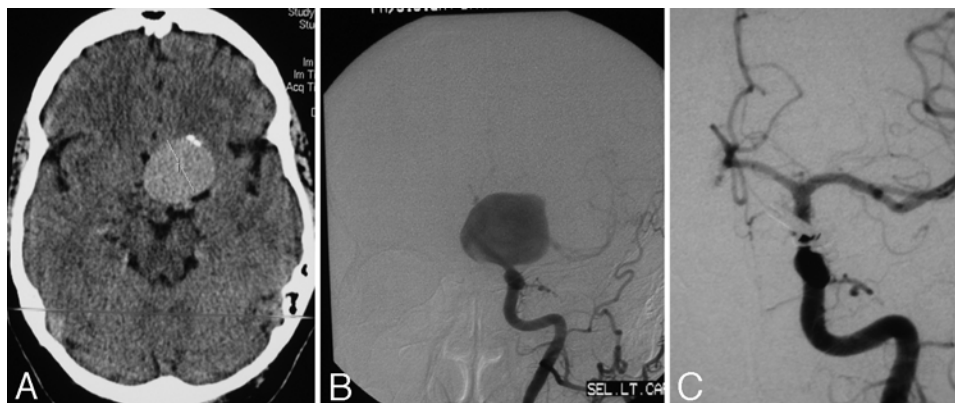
Case 12. A: Preoperative CT. B: Preoperative anteroposterior angiogram. C: Postoperative anteroposterior angiogram.
